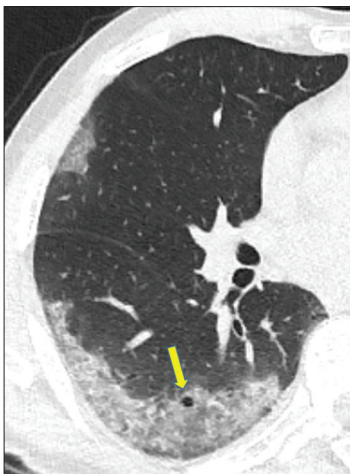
A 58-year-old male coronavirus disease 2019 patient presenting with fever and dry cough for 10 days. A computed tomography scan shows consolidation with an air bubble sign (yellow arrow) in the right lower lobe
